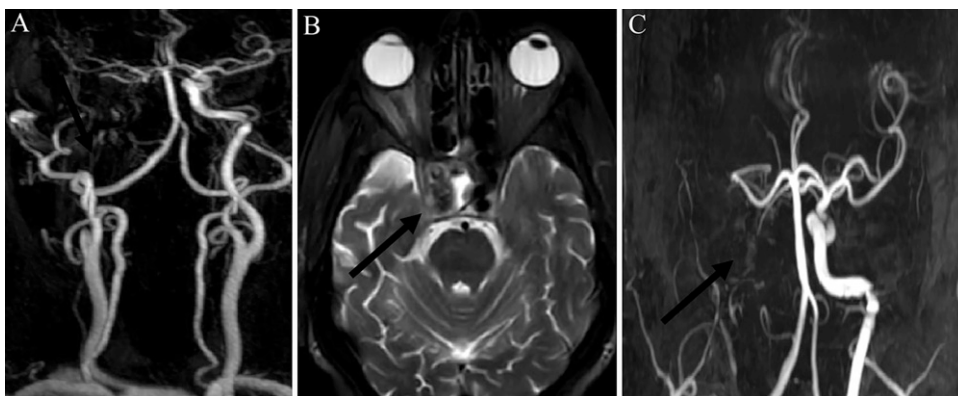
Arterial MRA (A and C) shows that the right ICA is totally occluded and there is no blood flow (*arrows*). On the axial T2-weighted MRI sequence (B), no flow is evident in the right ICA and there is coil material (*arrow*).
